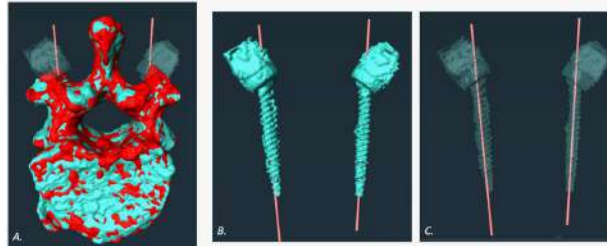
OnPoint Alm-AR system: A. Registration of intra-operative spin (cyan) with post-operative CT (red). B.&C. Comparison of post-operative screw position (cyan) with intra-operatively planned trajectories (pink); screws are shown with greater transparency in C.
